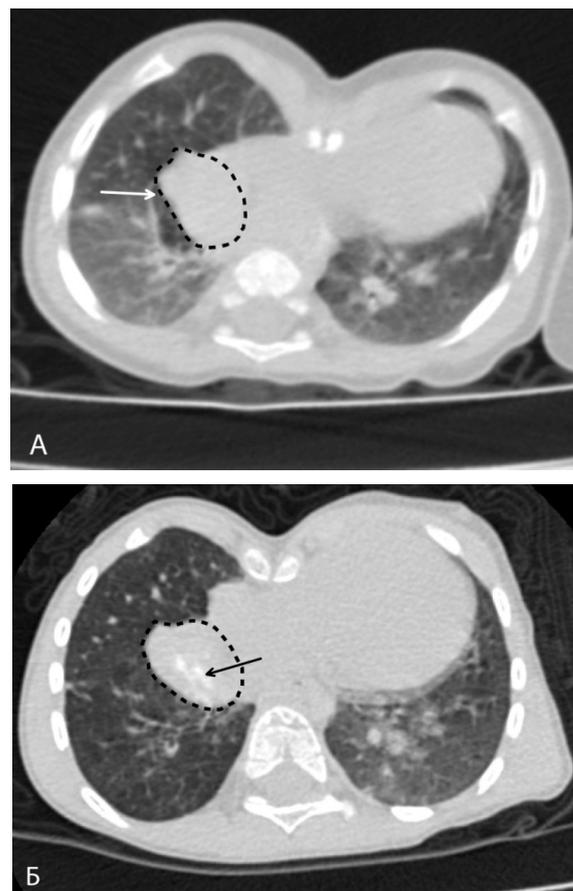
CT of the chest. Axial cut: A – one year after cardiac surgery: volumetric formation in the projection of the basal segments of the right lung and middle mediastinum (white arrow); B – three years after cardiac surgery: right-sided volumetric soft tissue formation of the middle mediastinum, which was 28×27×28 mm in size with calcified fragments (black arrow)
